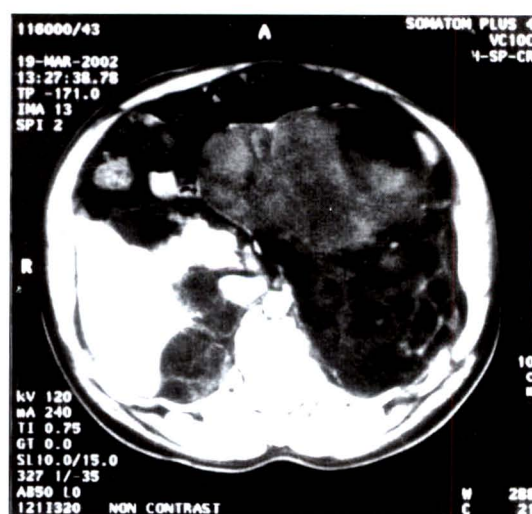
Bilateral large adrenal masses are apparent in an abdominal CT scan.
